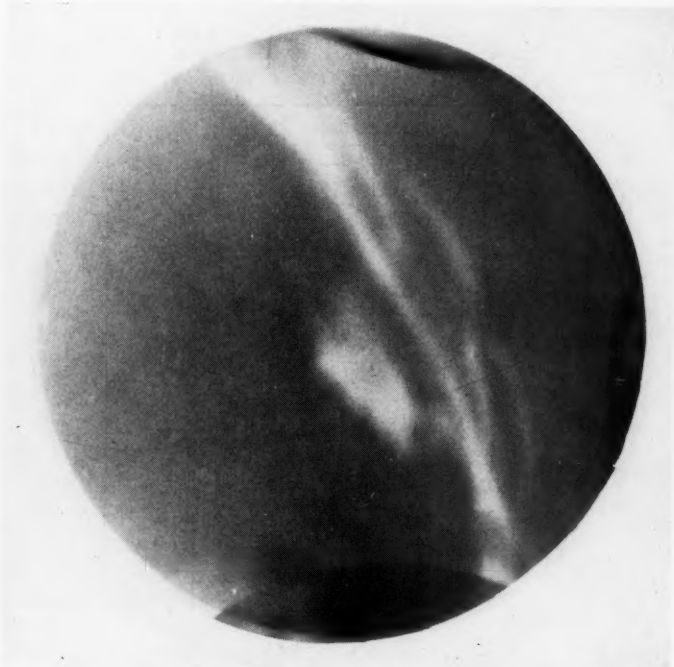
X-ray in case 2, showing a gastric ulcer of doubtful benignity. This patient was not operated upon because of severe cardiac disease.
